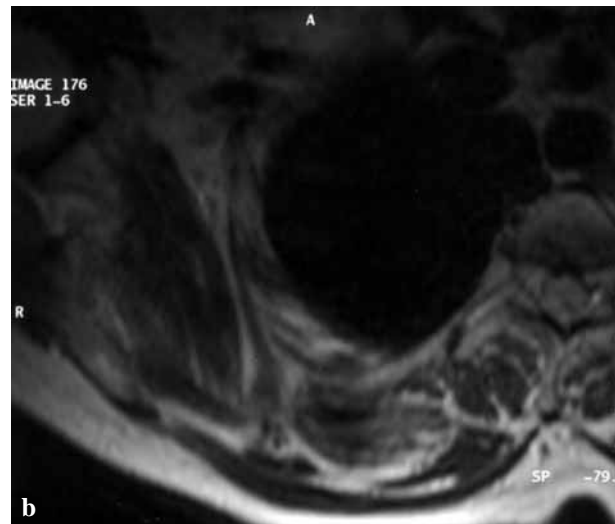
T1-weighted and T2-weighted images of the thorax showing a right subscapular mass. The lesion shows typical MR signal intensity characteristic of elastofibroma = mass with signal intensity similar to that of adjacent skeletal muscle, with interspersed linear areas of high signal intensity.
